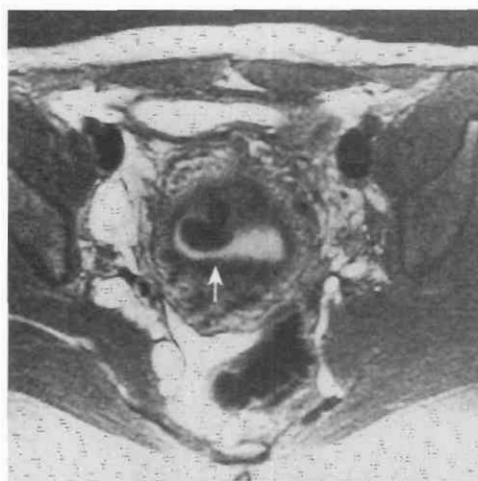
Submucosal leiomyoma in a patient with menorrhagia. Axial T2-weighted, fast spin-echo image (TR = 3500 msec, TE_{eff} = 80 msec) demonstrates a submucosal leiomyoma protruding into the endometrium (arrow). Incidentally noted are plexiform neurofibromas along the sciatic nerve in this patient with neurofibromatosis. TE_{eff}, effective echo time.
